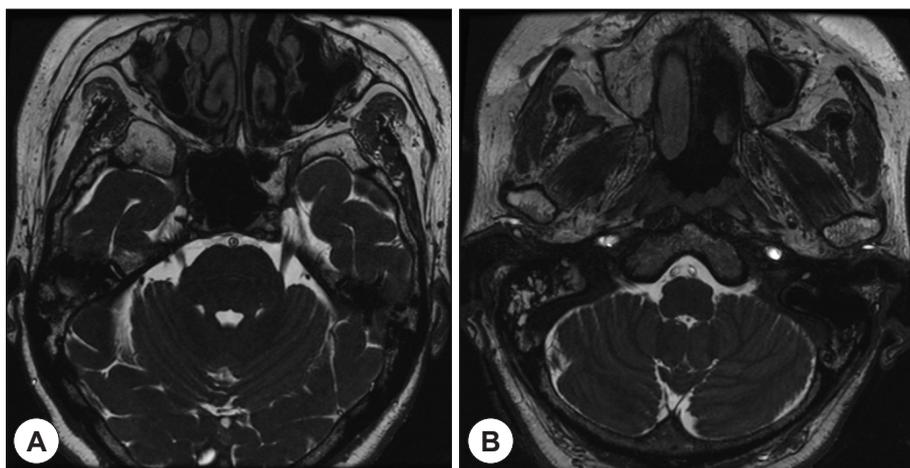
No artery or vein appeared to cause the trigeminal neuralgia, and no artery or vein traversed the glossopharyngeal nerve in magnetic resonance imaging.
